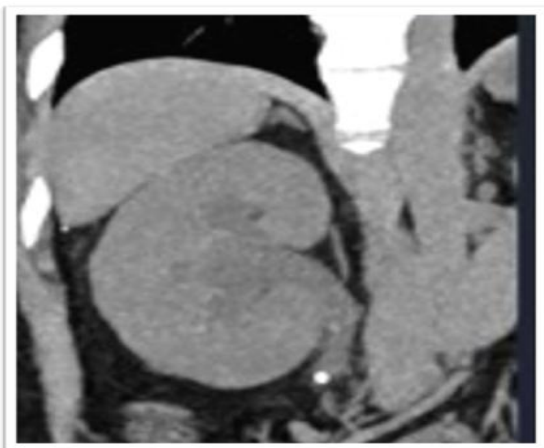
Non-contrast coronal CT image demonstrating a right upper ureteric calculus with upstream hydronephrosis, confirming the cause and level of obstruction.
